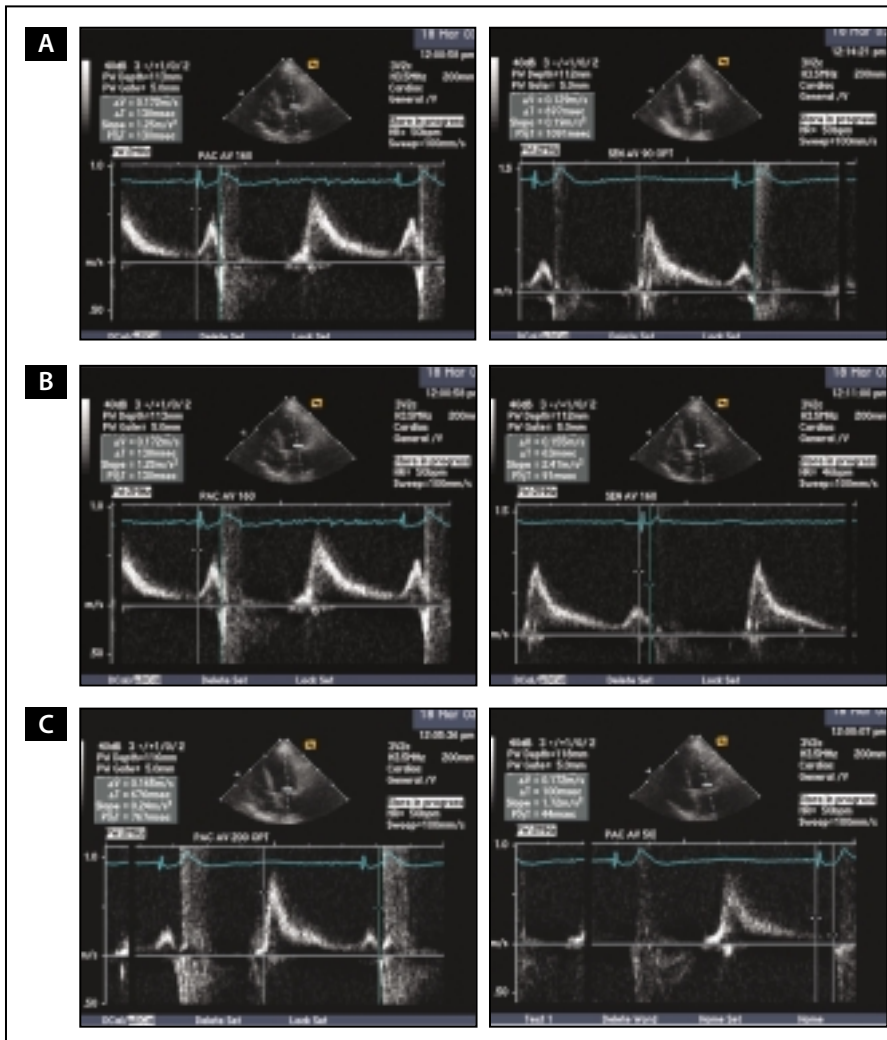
Two-dimensional echocardiography assisted by continuous-wave Doppler interrogation of the mitral annulus measure flow across the valve during a sequence of programmed atrioventricular delay (AVD) settings in the same patient. The ideal configuration for the mitral Doppler envelope demonstrates separation between the E and A waves, with maximization of the area contained below the envelope. The optimal AVD separates the E and A waves (optimizing active atrial filling) while maximizing the area under the envelope (mitral flow). (A) The optimal AVD during atrial sensing usually differs from the optimal AVD during right atrial pacing due to the intrinsic delay between right atrial pacing and left atrial contraction (90 ms during atrial sensing vs 160 ms during atrial pacing). (B) Setting the same AVD for atrial sensing (left panel) and atrial pacing (right panel) produces markedly different Doppler filling patterns that may not optimize cardiac function. (C) Excessively long or excessively short AVDs markedly impair the mitral filling pattern.
